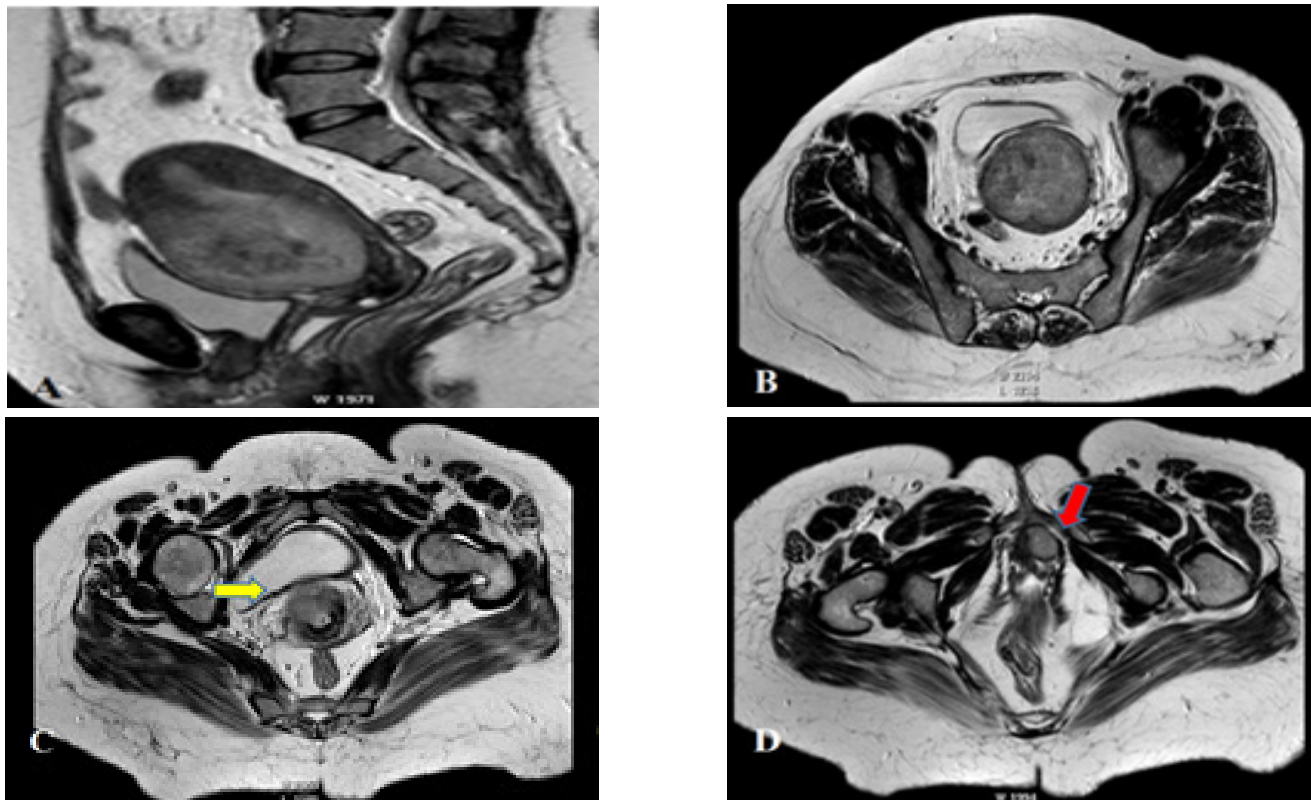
A 68-year old female patient with endometrioid adenocarcinoma. Conventional MRI findings (T2WIs): A large endometrial mass of intermediate signal intensity is seen. Indistinct junctional zone is noted on the axial images with suggested deep endometrial invasion, consequently the pre-operative staging by T2WIs was stage IB. DCE-MRI findings: The subendometrial zone shows preserved enhancing band suggesting absence of myometrial invasion, consequently the pre-operative staging by DCE-MRI was stage IAT3/ DW fused images suggest deep myometrial invasion (>50 %), i.e. Stage IB. the estimated ADC value is $0.724 \times 10^3 \text{ mm}^2/\text{sec}$. Consequently the pre-operative staging by DWI was similar to that of T2WIs as stage IB.
